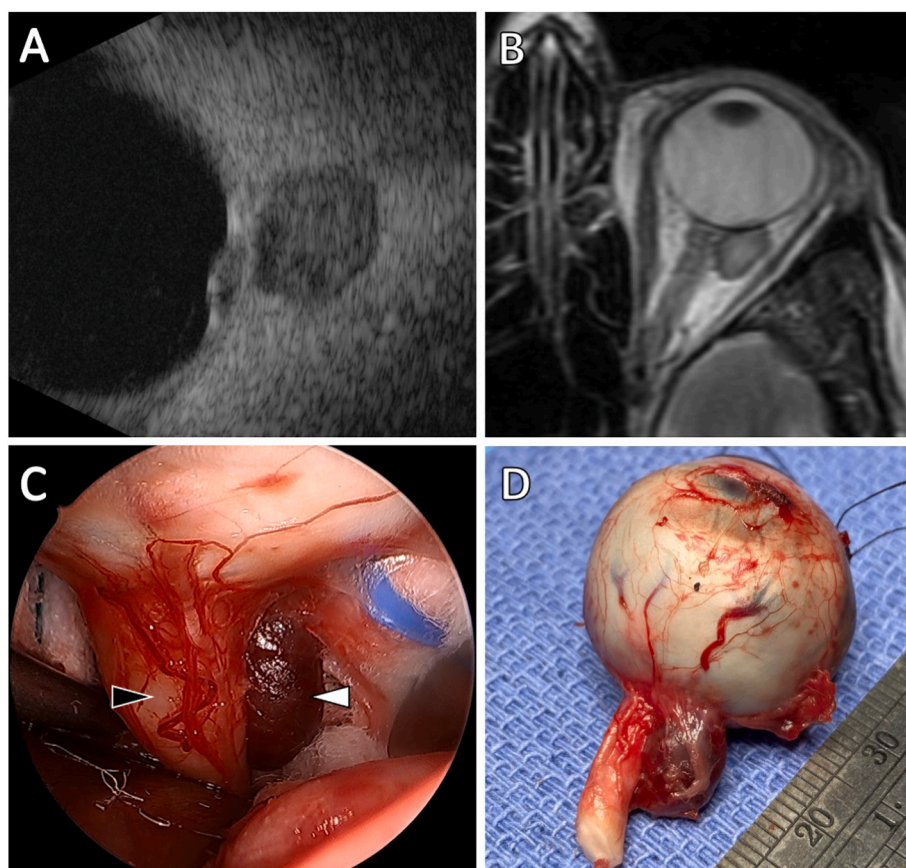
Transverse section on B-scan ultrasonography (A) and magnetic resonance imaging (B) depict a small intraocular dome-shaped choroidal mass and an associated extrascleral mass. The pigmented extrascleral tumor (white arrowhead) abuts the nerve (black arrowhead) on endoscopic (C) and gross visualization (D).
